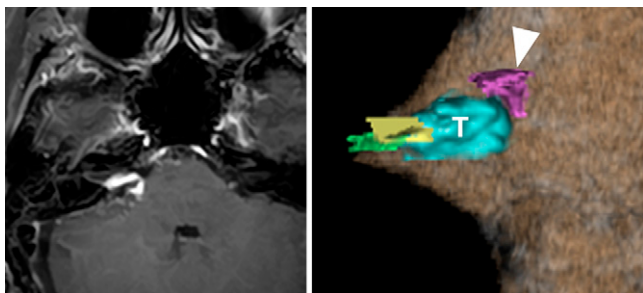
Postoperative axial gadolinium T1-weighted MRI (left) showing partial residual tumor capsules. 3D-MRC/MRA fusion image (right) showing sufficient decompression of the trigeminal nerve. Arrowhead indicates trigeminal nerve. T = tumor.
